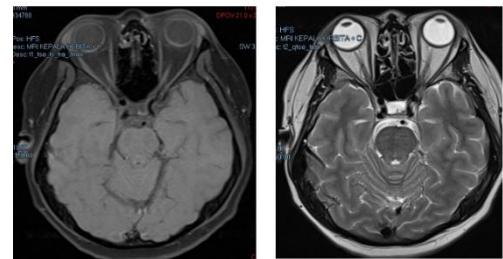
MRI Examination
